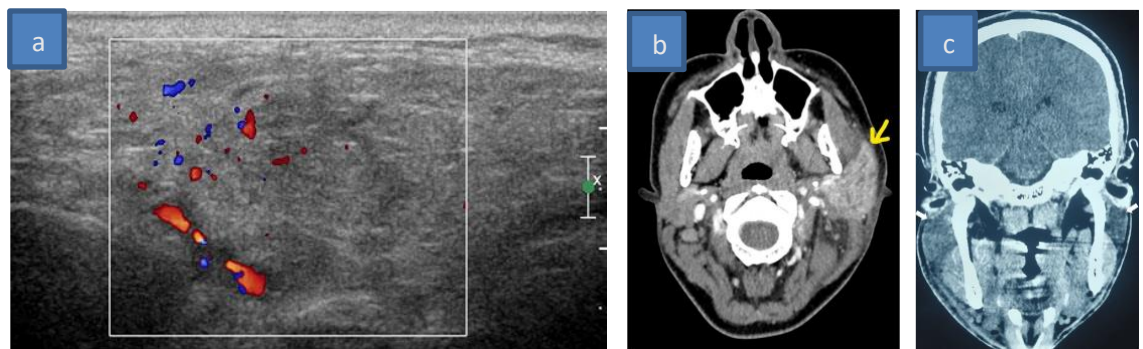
(A). USG with color doppler of the salivary gland: demonstrates an enlarged salivary gland with heterogeneous hypoechoic echotexture. Color Doppler reveals increased vascularity within the gland, indicating hyperemia associated with inflammatory changes.²⁴ (B). Axial CT Scan of the neck: demonstrates diffuse enlargement of the parotid gland (arrow) with increased attenuation of the surrounding soft tissues. There is evidence of fat stranding adjacent to the gland, indicating inflammatory changes. No abscess formation or focal mass is identified. These findings are consistent with salivary gland inflammation associated with mumps.¹ (C). MRI: hyperintense signals on T2-weighted images reflecting glandular edema, with homogeneous enhancement on post-contrast T1-weighted sequences indicating diffuse inflammatory involvement. The absence of focal mass or abscess formation further supports a diagnosis of viral sialadenitis, particularly mumps.¹⁷
